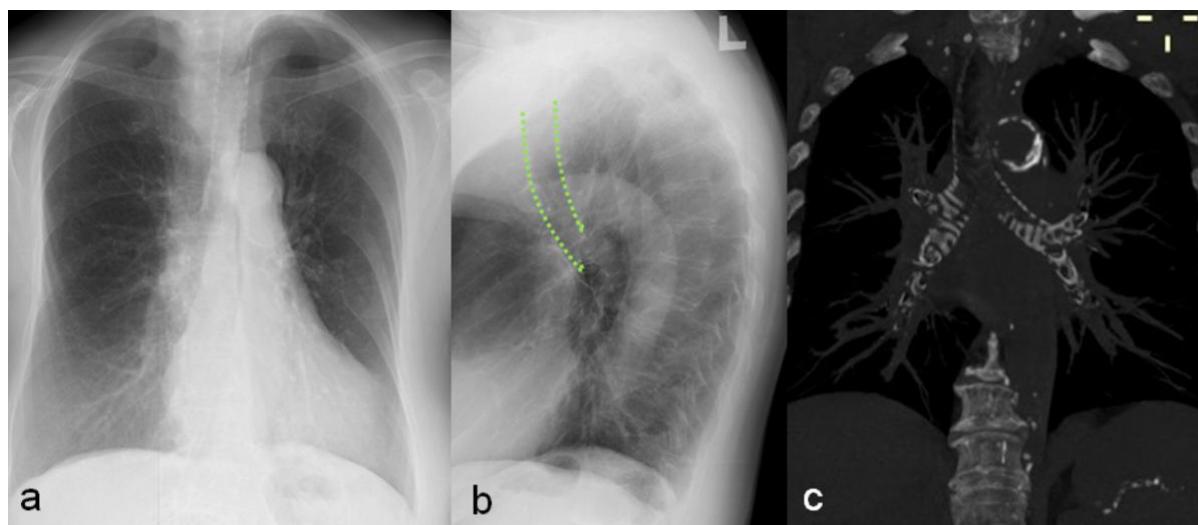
Chest X-ray (a,b) in a 76-year-old man show diffuse tracheo-bronchial calcification which can be better delineated on MIP reconstructions (c)
